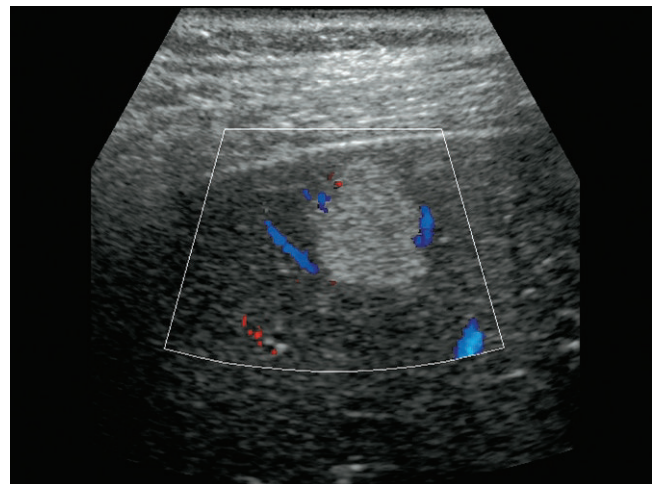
Color Doppler view of the same mass shows no flow within this mass, but vessels surrounding the mass.
